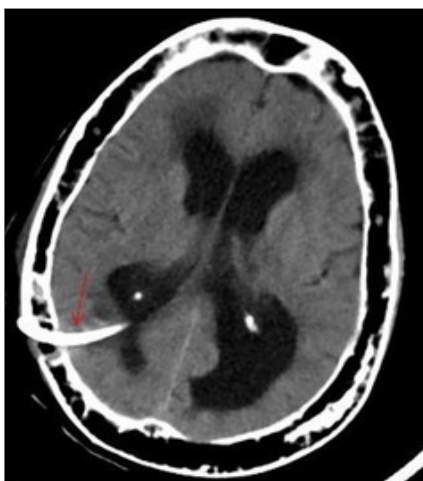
Axial CT image showing ventriculoperitoneal shunt (red arrow)
